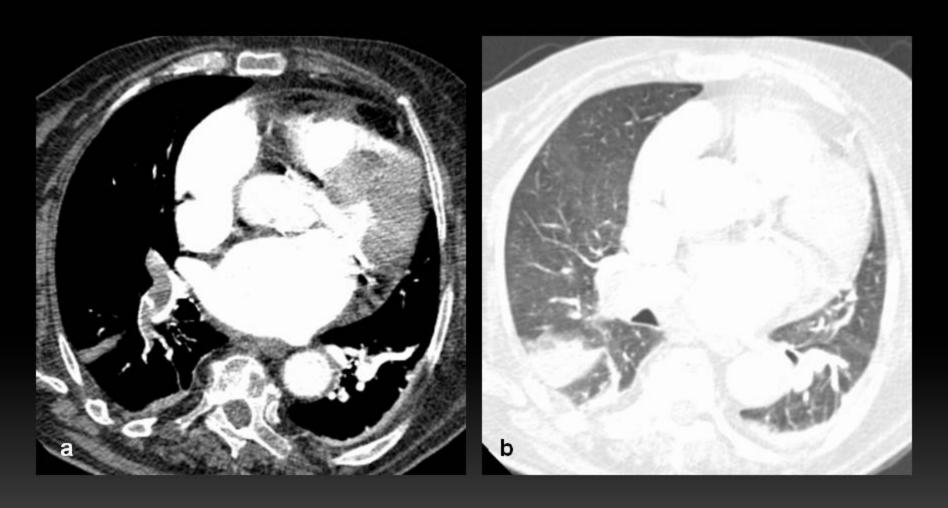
Man, 80 years old, with acute respiratory distress and hemoptysis. Thoracic CT shows cardiomegaly and filling defects (thrombi) in the right lower lobe artery and its branches (a). In lung windows (b), there is a wedge shaped opacity in the right lower lobe, surrounding by a ground - glass opacity (pulmonary infarct surrounded by hemorrhage).
